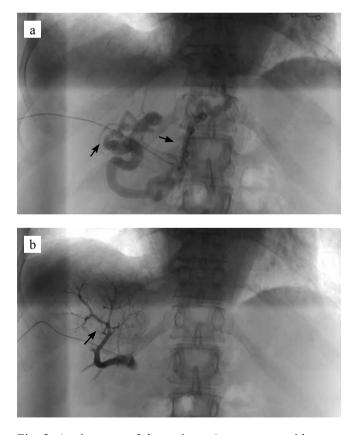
Angiograms of the patient. a) portogram with contrast agent injection at the rate of 1 mL/sec and 1.5 mL/sec: the portal vein trunk and collaterals were visualized (black arrows); b) portogram with contrast agent injection at a rate of 0.8 mL/sec: only the portal vein segmental branches were perfused (optimal speed) Ultrasound examination was performed after the operation. It found no bleeding at the manipulation site. There were no complications and clinically significant adverse events in the early postoperative period during the follow-up of the patient. The patient was discharged after 48 hours of hospital observation and control blood tests.
